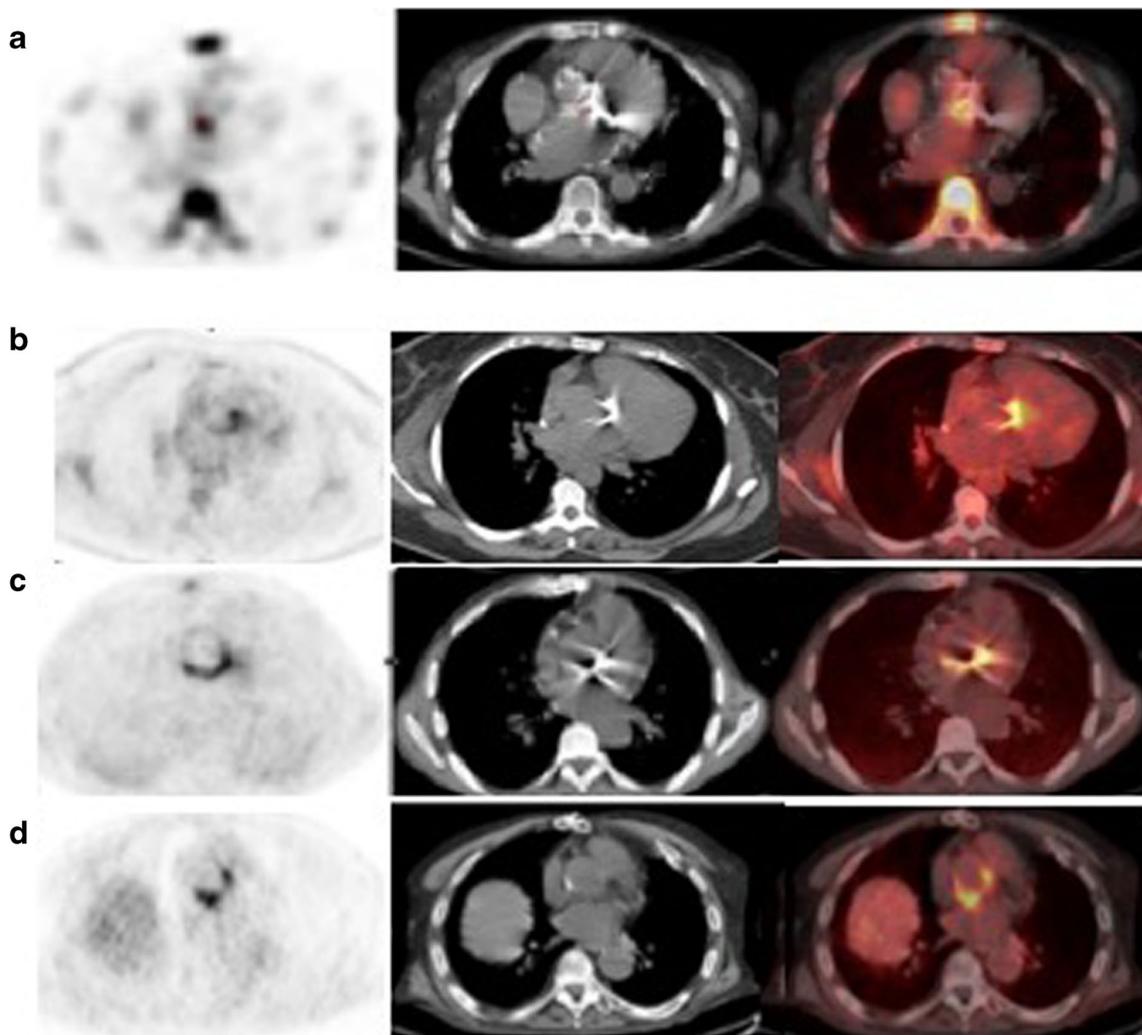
Examples of different patterns of $^{99\text{m}}\text{Tc}$ -HMPAO WBC and [^{18}F]FDG uptake in patients with confirmed PVE: a typical focal pattern at $^{99\text{m}}\text{Tc}$ -HMPAO WBC imaging; b focal pattern of [^{18}F]FDG;
